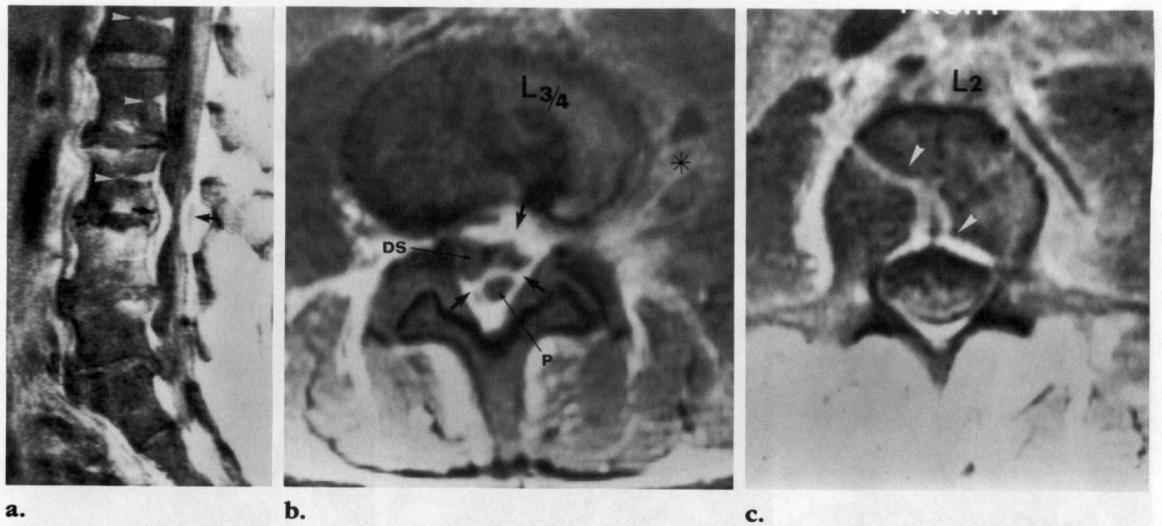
Case 20. A 48-year-old diabetic man with a history of drug abuse developed fever, backache, and weakness of his lower extremities. (a–c) Postcontrast sagittal (a) and axial (b, c) T1-weighted images show circumferential epidural enhancement causing stenosis of the dural sac (DS) at the L3-4 level (arrows in a and b). There is a collection of pus (P) in the posterior epidural space. Note extension of the inflammatory mass into the left paravertebral region (* in b). Prominent basivertebral veins are seen in the region of the upper portion of the lumbar spine on both sagittal and axial views (arrowheads in a and c). After completion of 8 weeks of antibiotic therapy, the patient complained of weakness of his lower extremities but had no clinical evidence of inflammation (*Fig 7 continues*).
